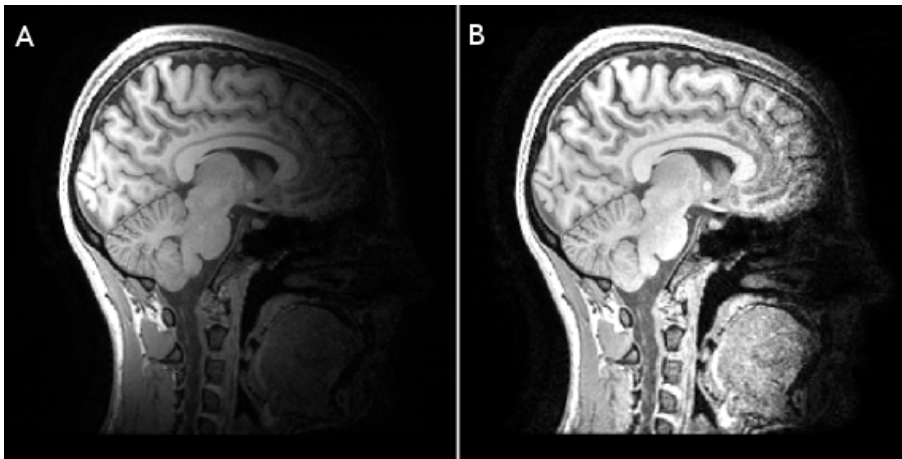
Example of an uncorrected (A) and fast corrected (B) T1-weighted structural isotropic image acquired with a 16 channel half-head posterior array coil. The image demonstrates the signal loss drop off towards the frontal cortex.
